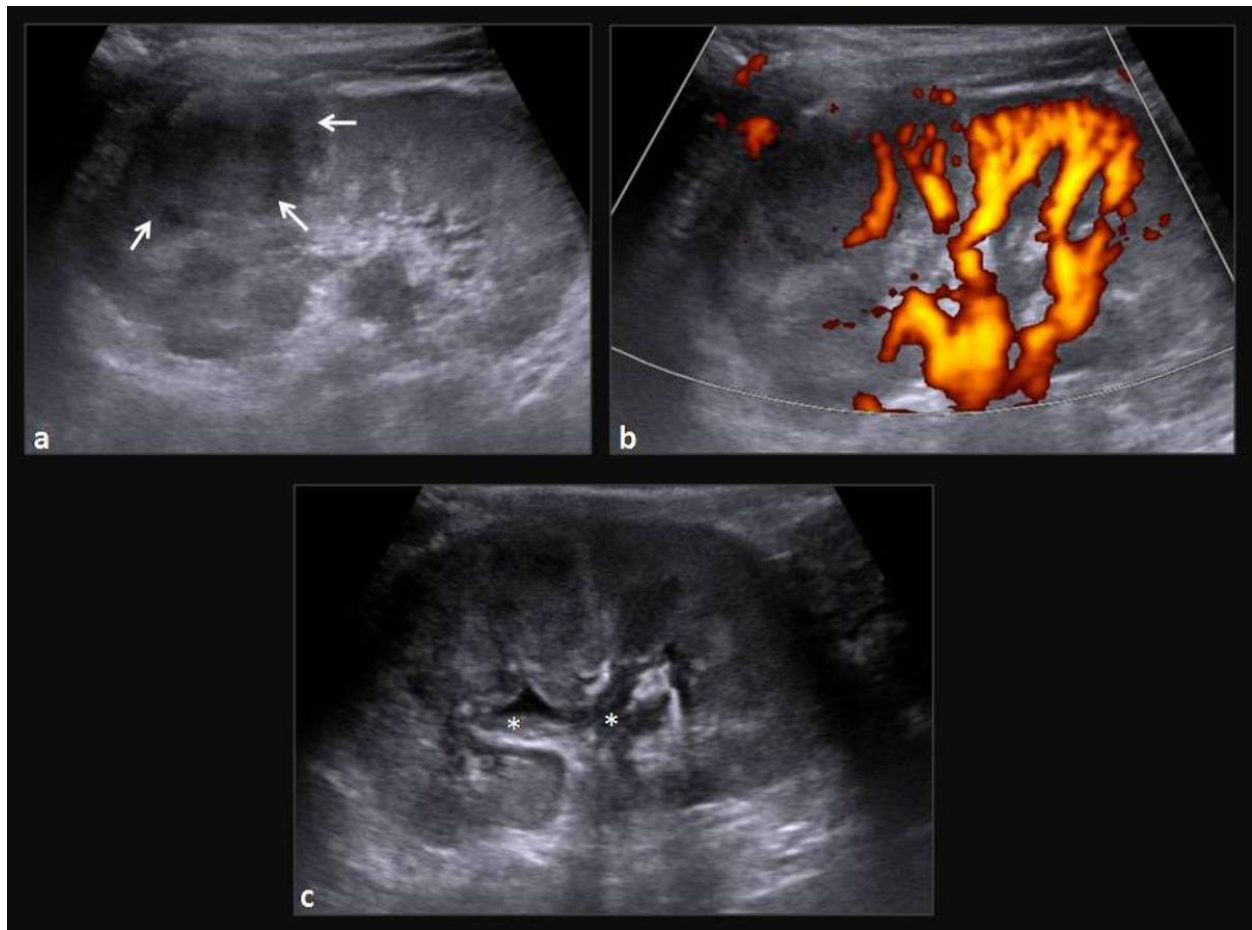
Focal acute pyelonephritis. (a) US scan demonstrates a hypoechoic "mass" (arrows) in the upper pole of the right kidney, a finding that is worrisome for a solid tumor. (b) Power Doppler image demonstrates diminished flow through the involved area. (c) There is also thickening of the walls of the collecting system (*).
